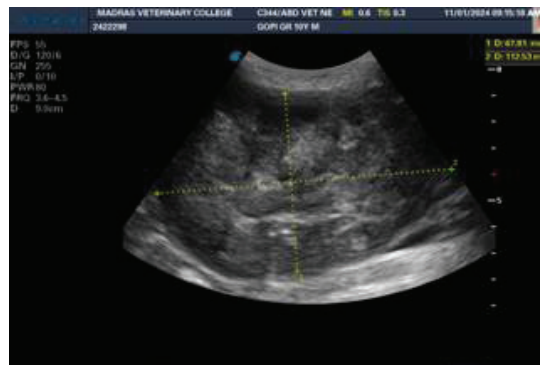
Ultrasonography of testicular tumour
